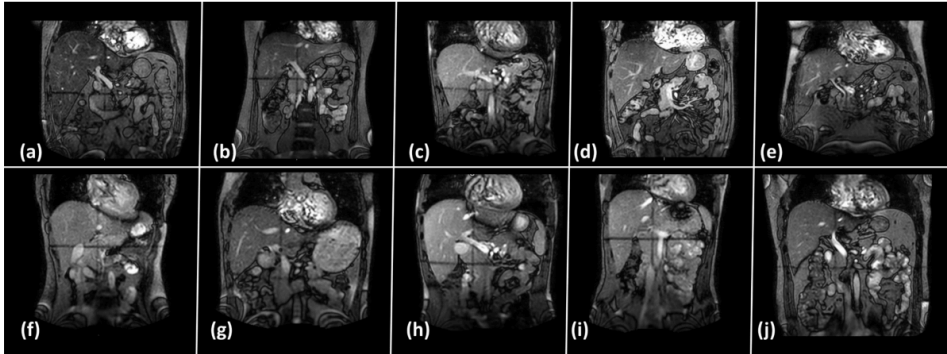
Coronal cine MR images showing intensity variation between volunteers.
